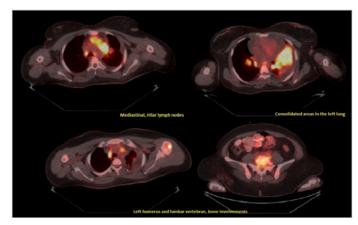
PET-CT imaging - Mediastinal, hilar lymph nodes. Consolidated areas of the lung. Bone involvement.
